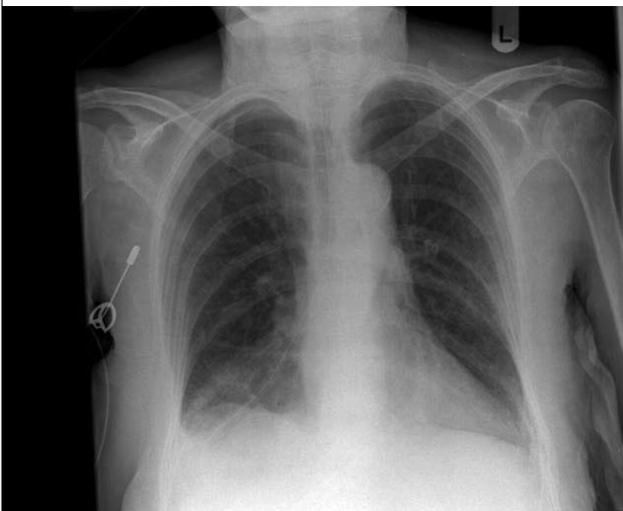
Chest X-ray the next day, showing right sided pleural effusion and collapse of the right lower lobe
